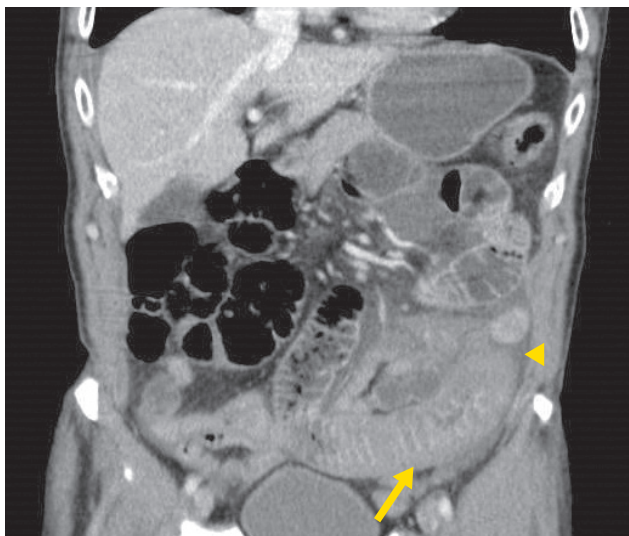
Coronal abdominal computed tomography: intramural hyperdensity and circumferential thickening with luminal narrowing of a small bowel loop, suggestive of intramural jejunal hematoma (arrow), and hemoperitoneum (arrow head)
